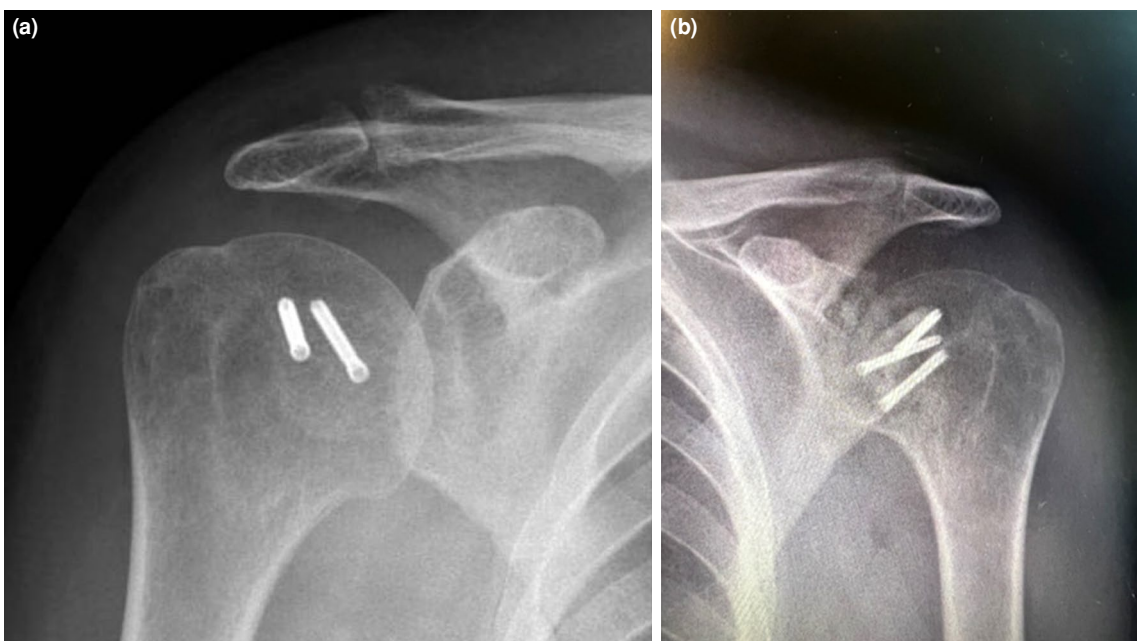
Postoperative anteroposterior radiograph of the shoulder showing that the shoulder is reduced and the head has the expected hemispheric appearance. (a) Right, (b) Left.
